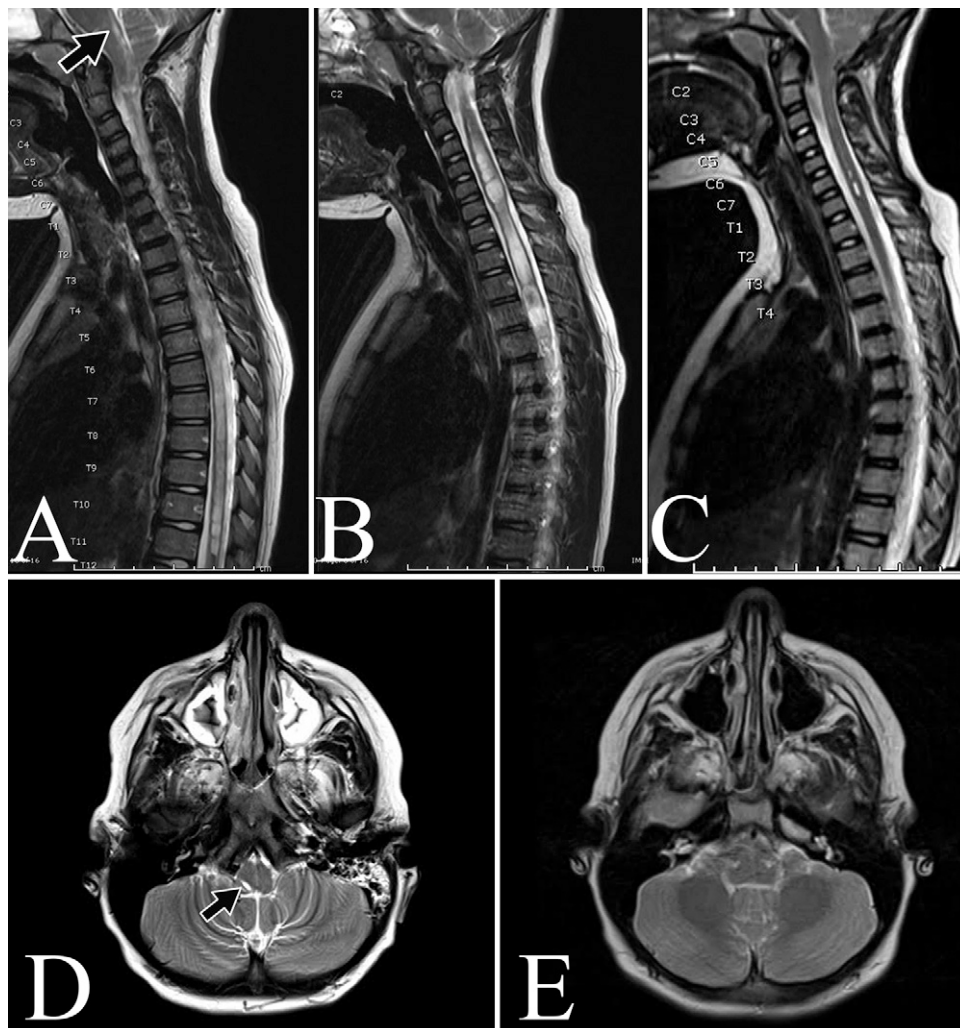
A: Preoperative sagittal T2-weighted MRI demonstrating the extent of a syrinx (*arrow*) in the brainstem. B: Preoperative sagittal T2-weighted MRI. C: Two-month postoperative sagittal T2-weighted MRI. D: Preoperative axial T2-weighted MRI demonstrating the extent of the syrinx (*arrow*) in the brainstem. E: Two-month postoperative axial T2-weighted MRI.
